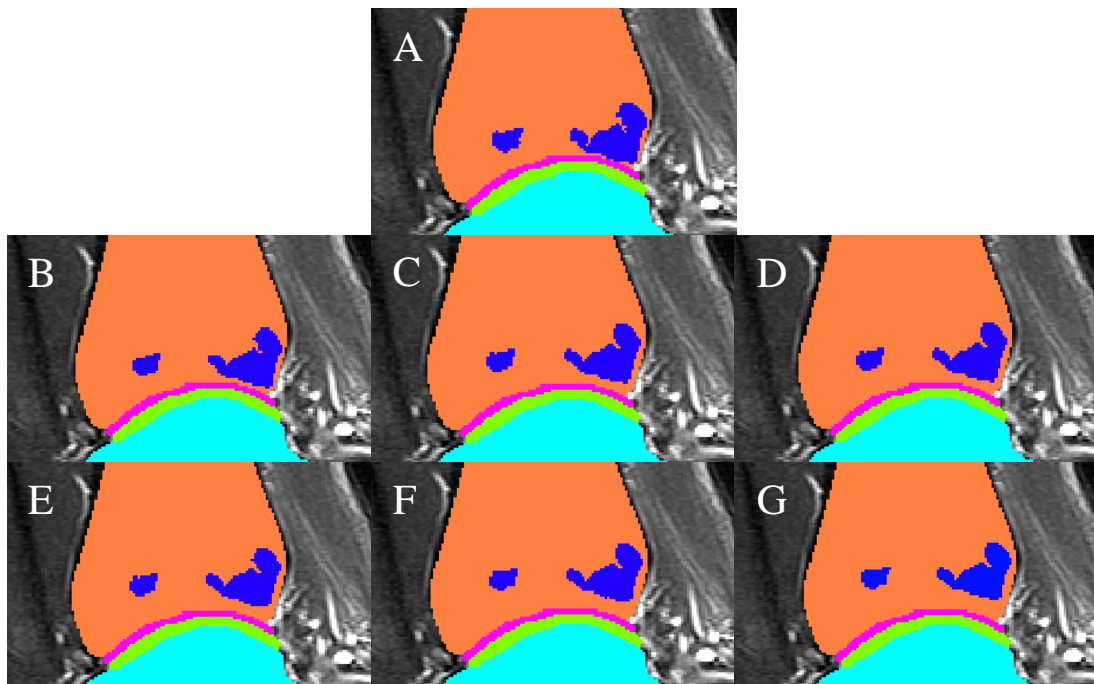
Translation of cyst segmentation on the same MRI slice. A) baseline segmentation from image; B) +0.5mm from baseline; C) +1mm from baseline; D) +1.5mm from baseline; E) +2mm from baseline; F) +2.5mm from baseline; G) +3mm from baseline.
